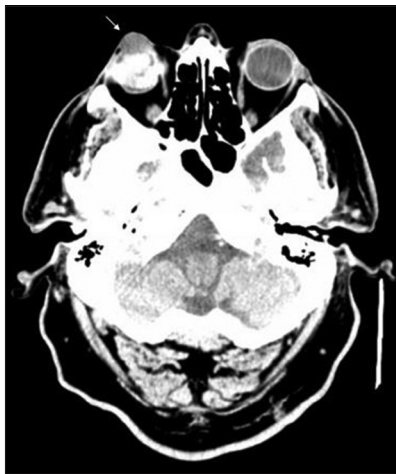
Computed tomography scan of the orbit showing a soft tissue mass between the anterior pole of the right eye and its tarsal conjunctiva (arrow)
